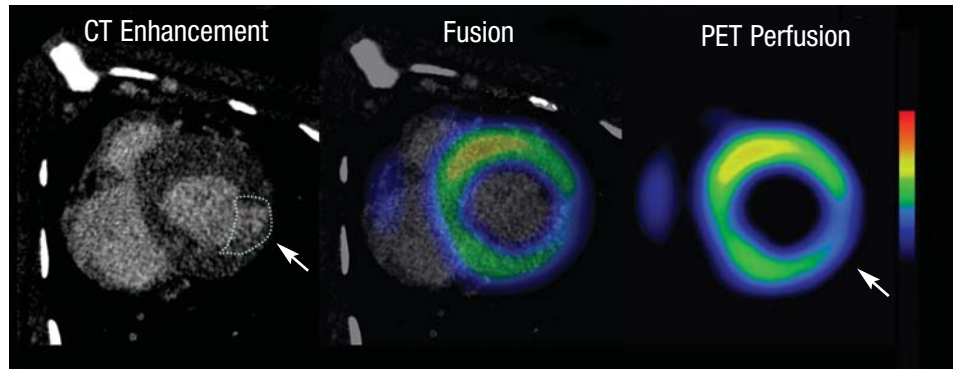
Delayed enhancement of contrast agent in repeat CT acquisition five minutes after injection. There is contrast retention in inferolateral wall of short-axis CT image (left), consistent with perfusion defect, as shown on Rb-82 perfusion PET (right, fusion image shown in the middle).
